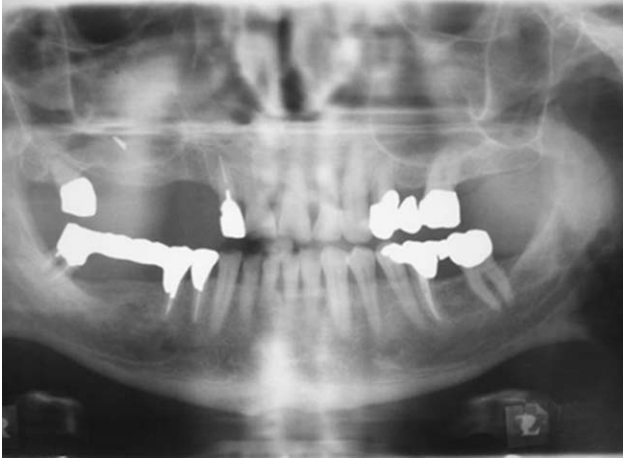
Preoperative panoramic x-ray demonstrating insufficient bone for implant placement in the posterior right maxilla.
